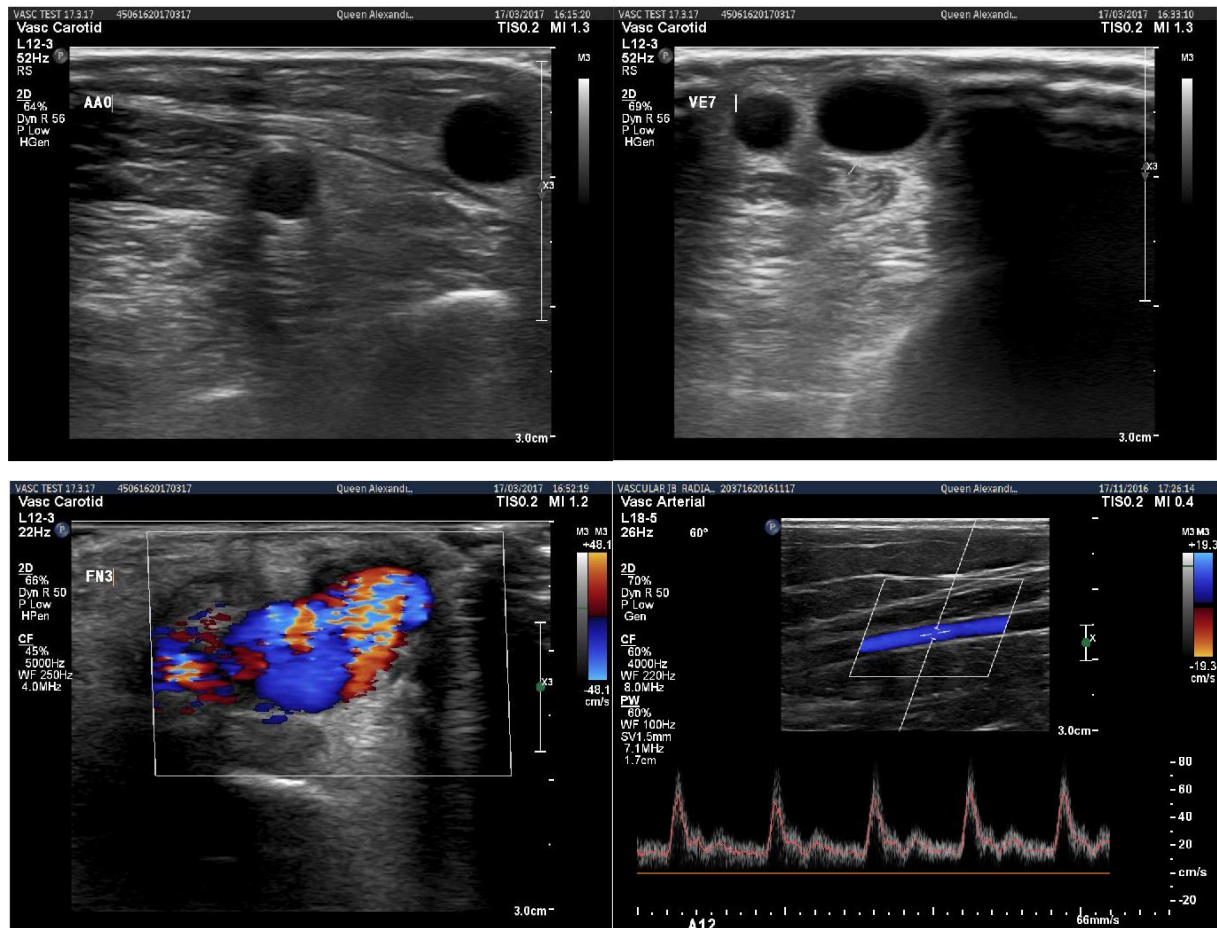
Two Mode-B scans of the vein and artery cross-sectional area (upper left and right); a Colour-Doppler scan at the anastomosis (lower left); a Doppler velocity scan (lower right).
